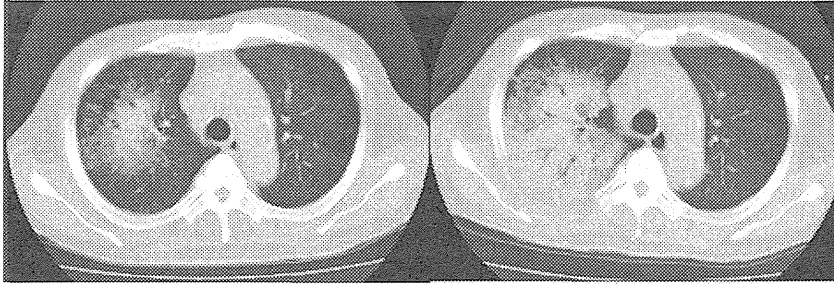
Patient 6 underwent cord blood transplantation for acute leukemia. Pneumonia developed when the neutrophil count was 0/ μ L on day 7 after transplantation. Compared with chest computed tomography on day 7 after transplantation (left), consolidation accompanied by an air bronchogram showed rapid expansion in the right lung field on the following day (day 8) (right).
